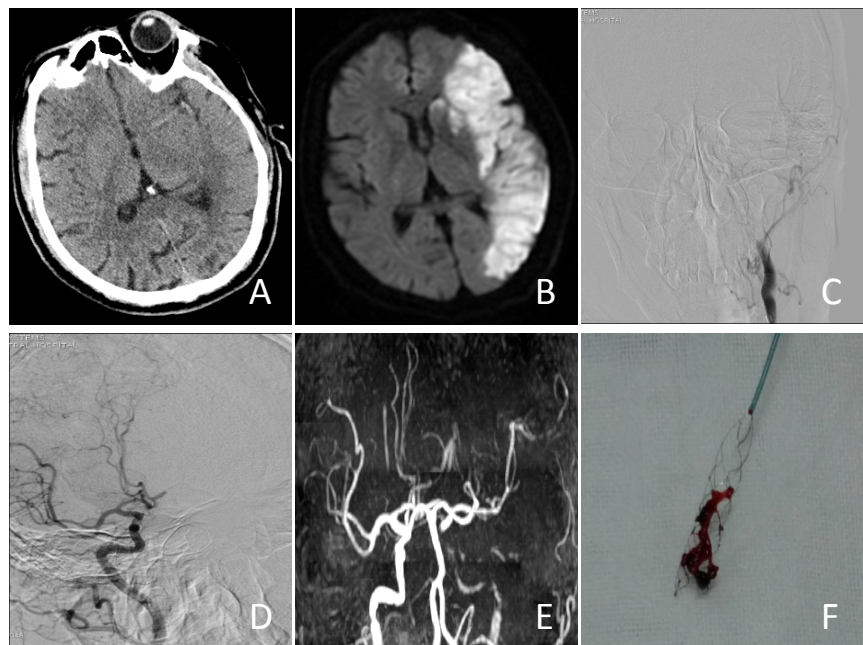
Patient 3: A wake upstroke patient who suffered from internal carotid artery occlusion. In 3a, it is shown that a high density sign covered on the left side of MCA. In 3b, the DWI showed the acute ischemic stroke of the left MCA after one day. In 3c and 3d, the DSA images show the left internal carotid artery occlusion. In 3e, the left MCA shows complete recanalization after the thrombectomy, and the clot could be seen in 3f.
